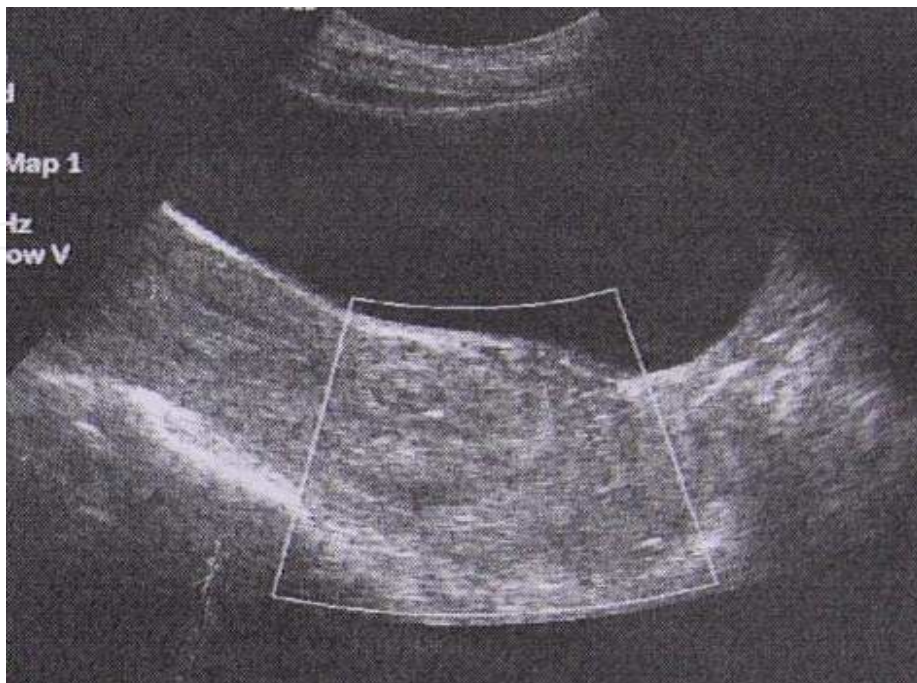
Transabdominal ultrasound image of pregnancy in low uterine corpus
